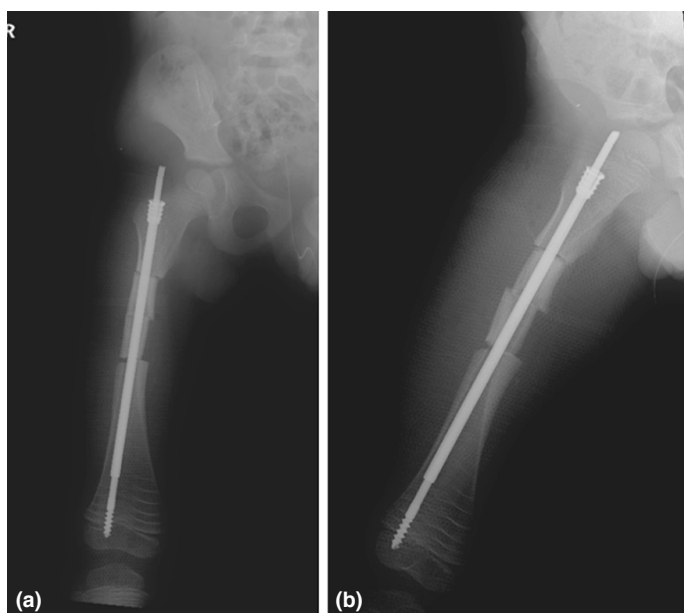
X-ray images of the patient after the telescopic nailing surgery. (a) Right femur ap view. (b) Right femur lateral view.
